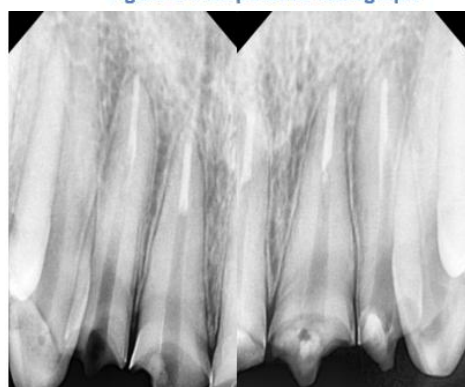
Post space preparation radiograph
